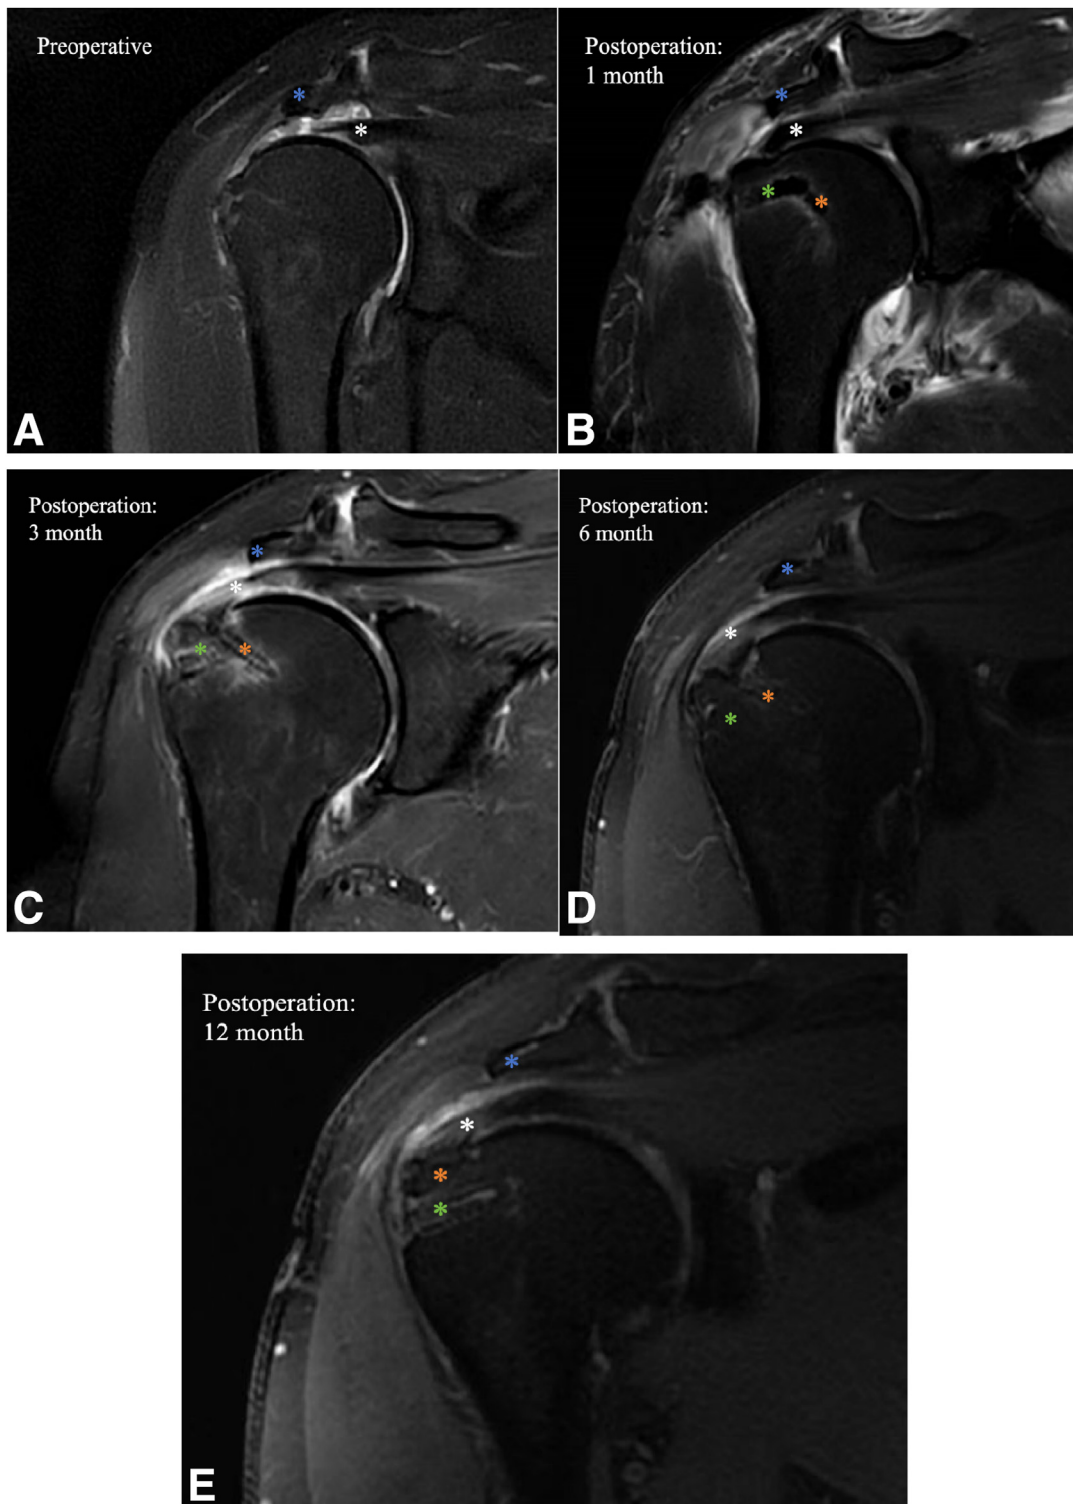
(A) Preoperative T2-weighted coronal MRI. (B-E) 1, 3, 6, and 12 months' postoperative T2-weighted coronal MRI. White asterisk: supraspinatus; blue asterisk: Acromion; orange asterisk: triple-loaded suture anchor (HEALIX ADVANCE BR Anchor; DePuy Mitek); and green asterisk: lateral-row anchor (HEALIX ADVANCE Knotless BR Anchor; DePuy Mitek). (MRI, magnetic resonance imaging.)
